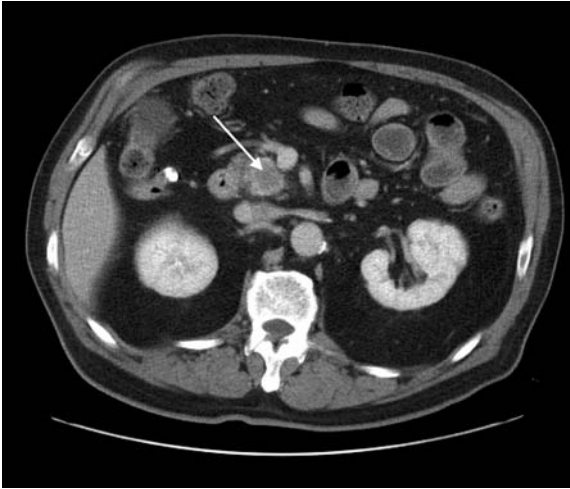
Computed tomogram showing pancreatic cancer. A small hypoattenuating lesion is seen in the head of the pancreas (*arrow*). The superior mesenteric vessels are not involved by the tumor, which is resectable.
